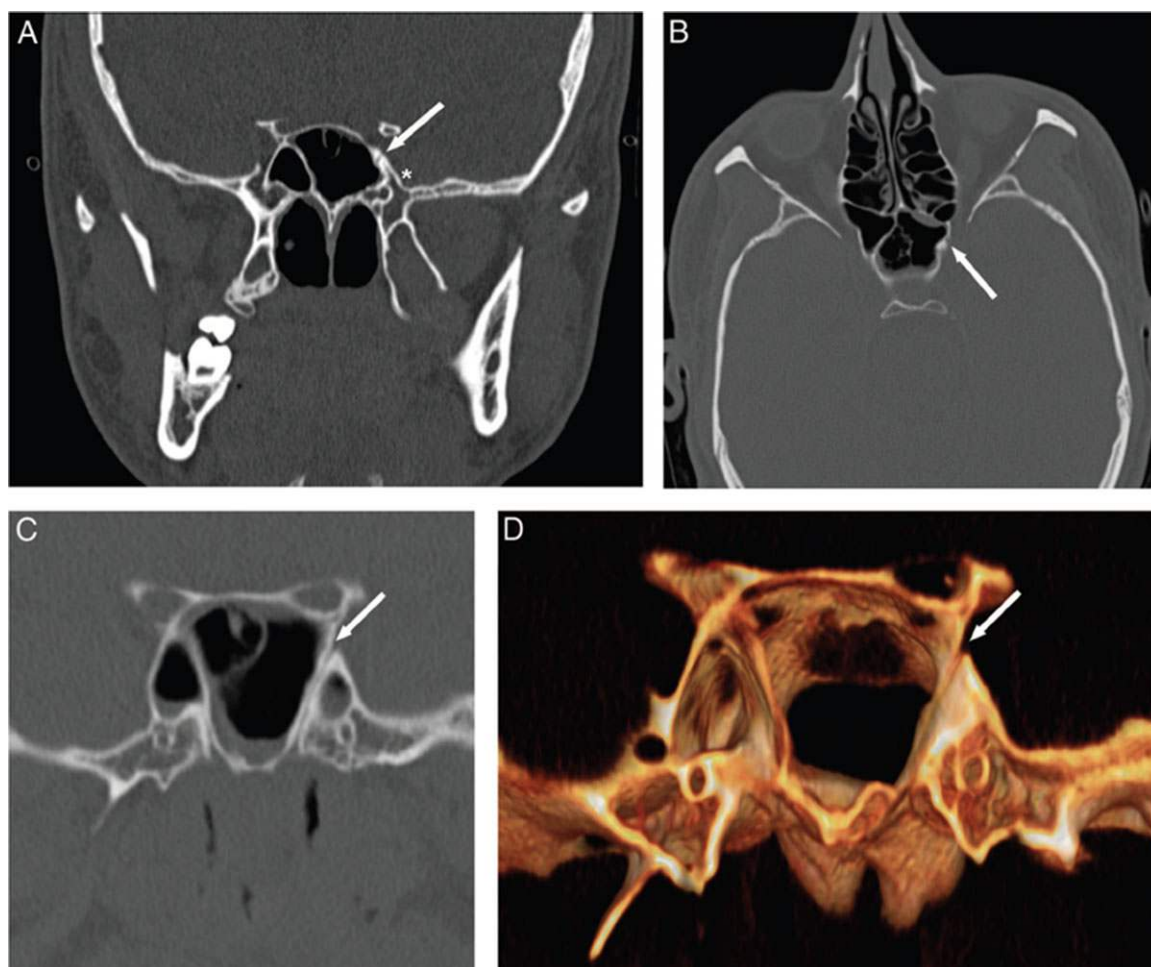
High-resolution CT scan of a patient with imaging findings consistent with Sternberg's description of the lateral craniopharyngeal canal. (A) Coronal and (B) axial images reveal a bony defect (arrows) located medial to the foramen rotundum and superior orbital fissure that opens in the region of the cavernous sinus. On (C) oblique CT and (D) three-dimensional reconstruction a canal is visualized in this area. The location of the second division of the trigeminal nerve (*) is highlighted on (A) the coronal image (reproduced with permission from Ref. 10). CT = computed tomography.
